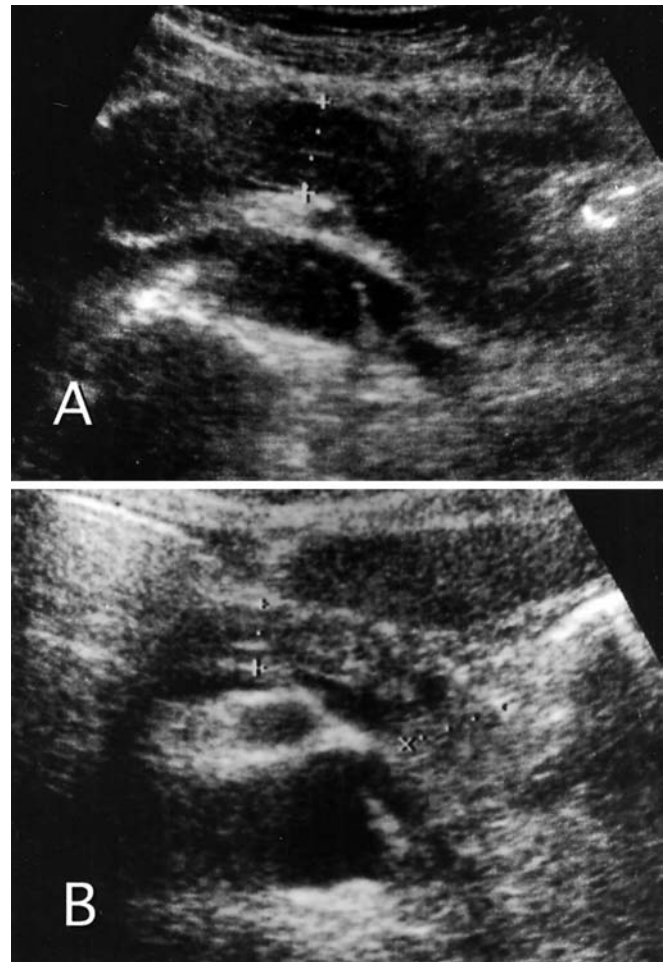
Abdominal ultrasonography. Before steroid therapy, the pancreas is diffusely swollen with low echogenicity of the parenchyma (A). Three months after steroid therapy, the pancreas swelling has disappeared (B)
